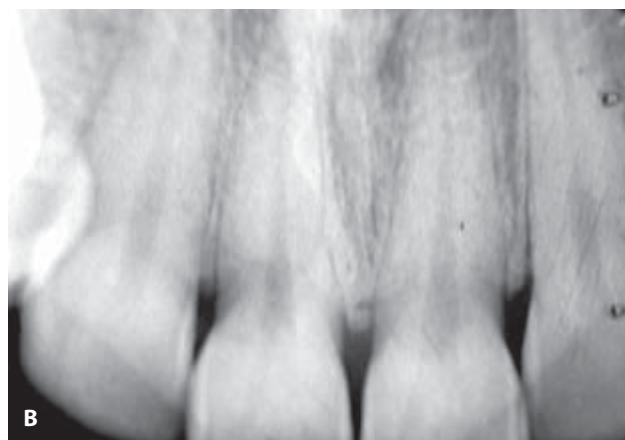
Periapical view showing the morphological characters of the thick flat tissue biotype. Note the reduced interradicular bone thickness.
